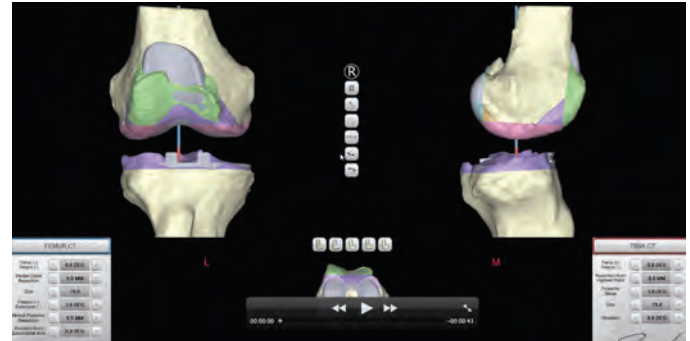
Personalised Knee replacement computerised model generated from MRI or CT scan of patient's knee. The computerised model can be adjusted by the surgeon to meet appropriate criteria. (clinical - signature)
